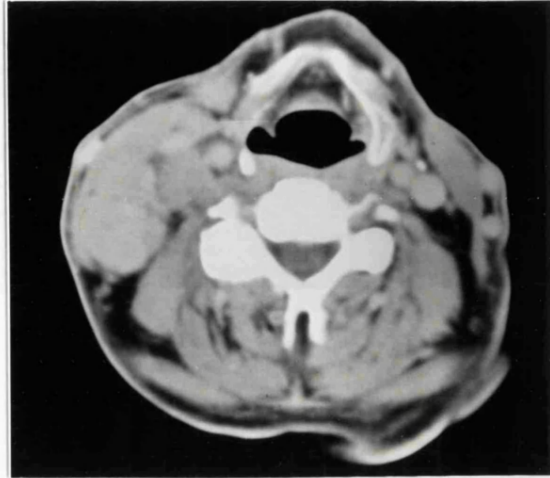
CT scan at level of thoracic inlet showing tumour encircling the trachea.
